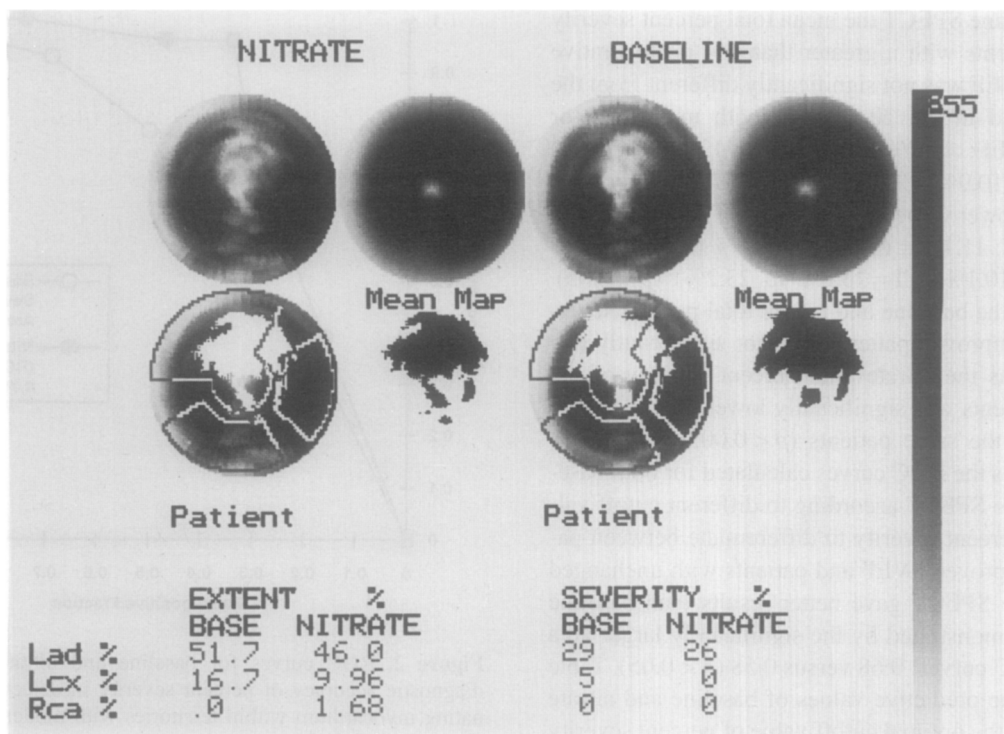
Polar map displays of patient with left anterior descending (*Lad*) obstruction and anteroapical akinesis. On left, nitrate study: upper left map depicts patient's count distribution; lower left map shows in white uptake defect (activity <2.5 SDs below normal limit); upper right map is database count distribution (mean map); uptake defect is shown in lower right panel. On right, baseline study is shown with same image disposition. Analysis of defect severity indicates that left anterior descending and left circumflex (*Lcx*) territories should be classified as viable in both baseline and nitrate SPECT. Left circumflex territory was normokinetic in prevascularization echocardiogram; left anterior descending territory showed significant recovery after coronary angioplasty. (*Rca*, Right coronary artery.)
